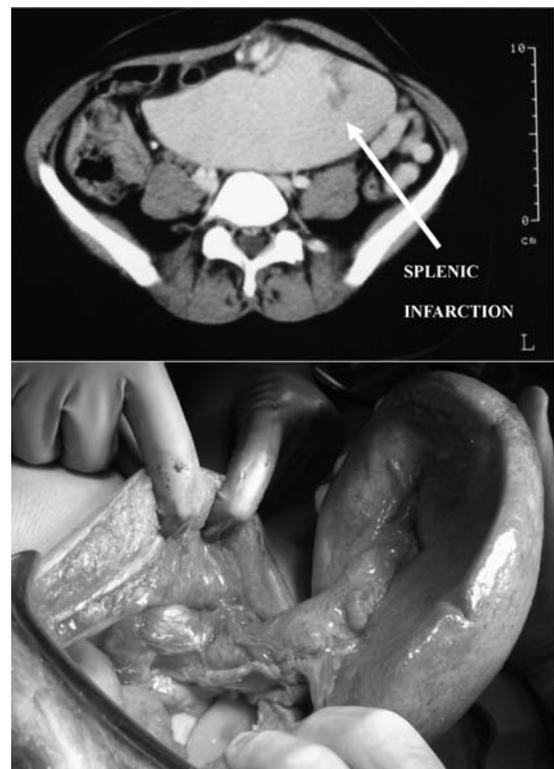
Wandering Spleen: CT-scan and surgical image.
